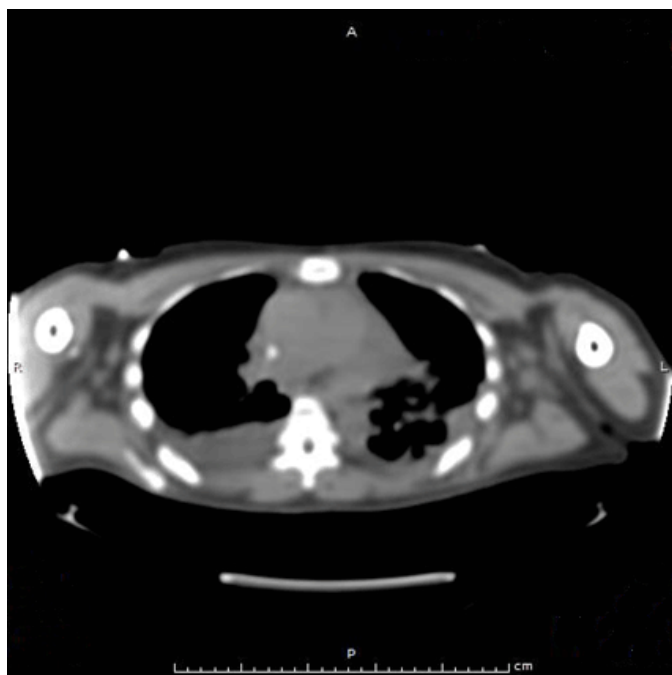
Thoracic computed tomography revealing a pericardial effusion.
